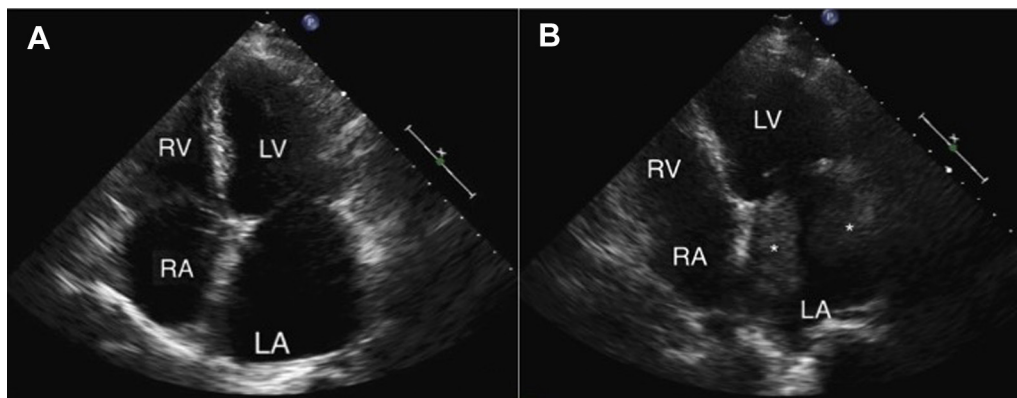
(A) Transthoracic apical four-chamber view (left) from echocardiography performed 11 months before admission showing left atrial enlargement but no filling defects in the left atrium (LA). (B) Transthoracic apical four-chamber view from admission echocardiography (right) showing two poorly defined filling defects in the LA (asterisk) (Supplemental Video 1). LV, Left ventricle; RA, right atrium; RV, right ventricle.
